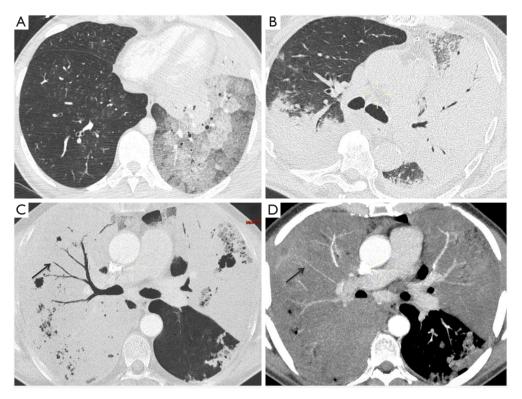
Main radiological features of ARDS related to diffuse P-ADC. (A) Intravenous contrast chest CT-scan shows ground glass attenuation predominant in the left lower lobe. (B) Intravenous contrast chest CT-scan shows bilateral and dense alveolar consolidation predominant in the left lung. (C) Parenchymal window: intravenous contrast chest CT-scan (MipPR: 10.0 mm) and (D) mediastinal window: injected chest CT-scan (MipPR: 10.0 mm) represent respectively the particular pattern of compressed bronchus (black arrow) and compressed pulmonary artery (black arrow) in a same patient, within a dense alveolar consolidation. We also note the presence of cavitation within the consolidation. ARDS, acute respiratory distress syndrome; P-ADC, pneumonic-type adenocarcinoma; CT, computed tomography.
